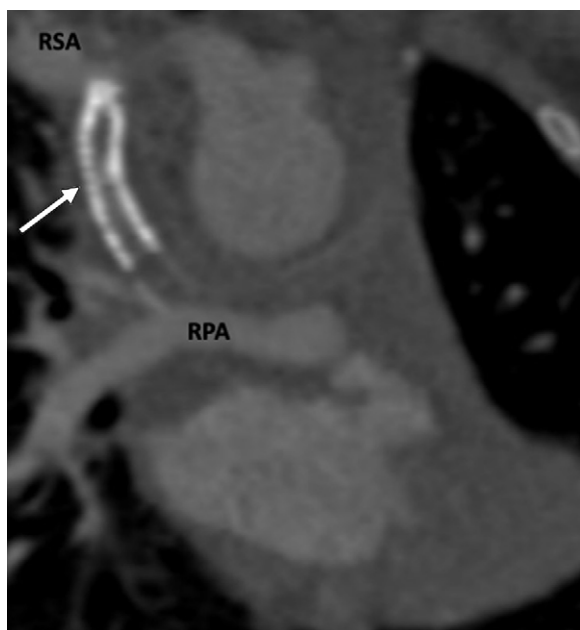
Postprocedural appearance of tetralogy of Fallot after modified BT shunt at birth followed by stent placement in a 3-month-old female infant. Coronal oblique contrast-enhanced CT image shows a stent (white arrow) in the modified BT shunt, which was made between the RSA and RPA at birth. The stent was placed to relieve stenosis of the BT shunt. The stent appears thrombosed and shows severe stenosis at the subclavian end. BT = Blalock-Taussig, RPA = right pulmonary artery, RSA = right subclavian artery.
